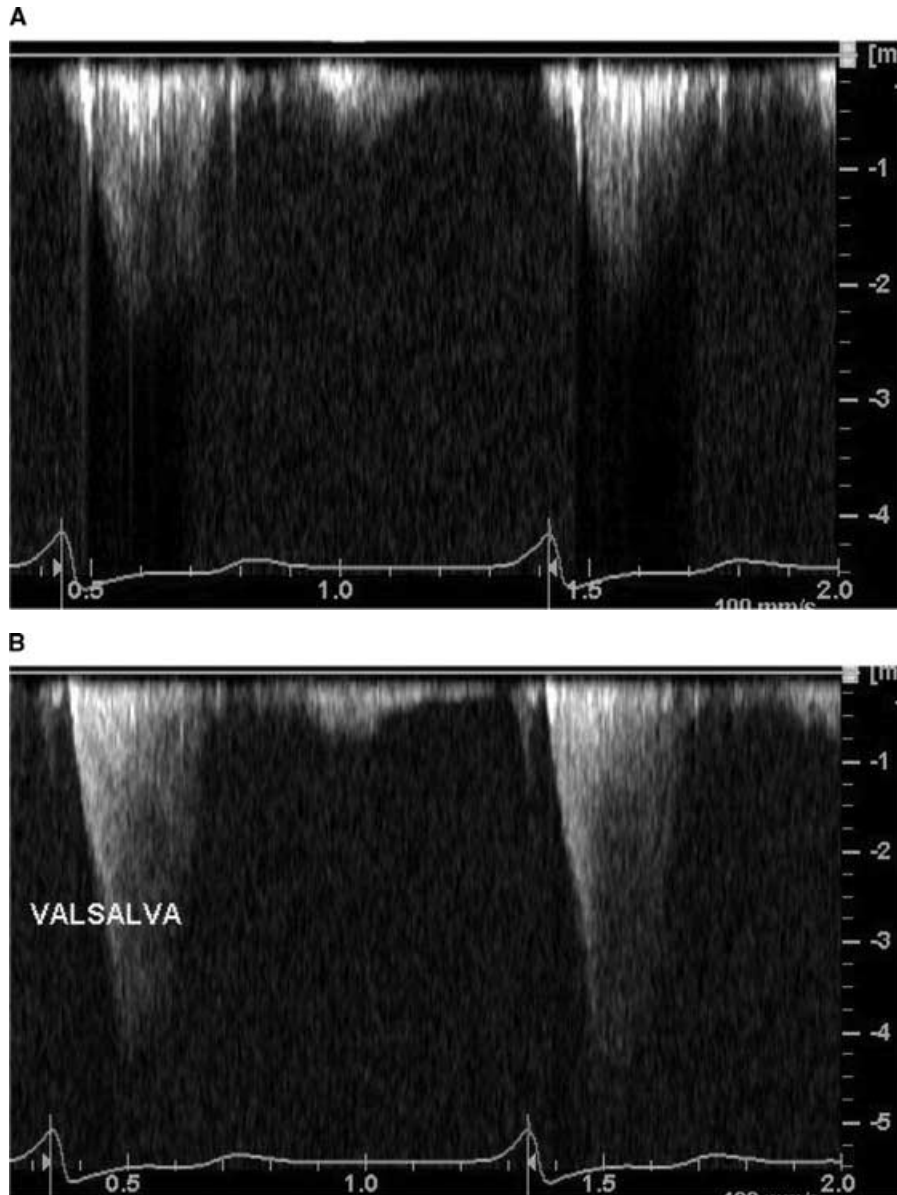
A 35-year-old female with exertional near-syncope and a murmur was referred for an echocardiogram. The patient was found to have classic hypertrophic cardiomyopathy with mitral systolic anterior motion and aortic valve mid-systolic closure. Continuous wave Doppler (apical five-chamber) of the left ventricular outflow tract (A) during normal respirations revealed a mid-systolic peak velocity of 2.25 m/sec. B. With the Valsalva maneuver the gradient increased to 4.5 m/sec.
